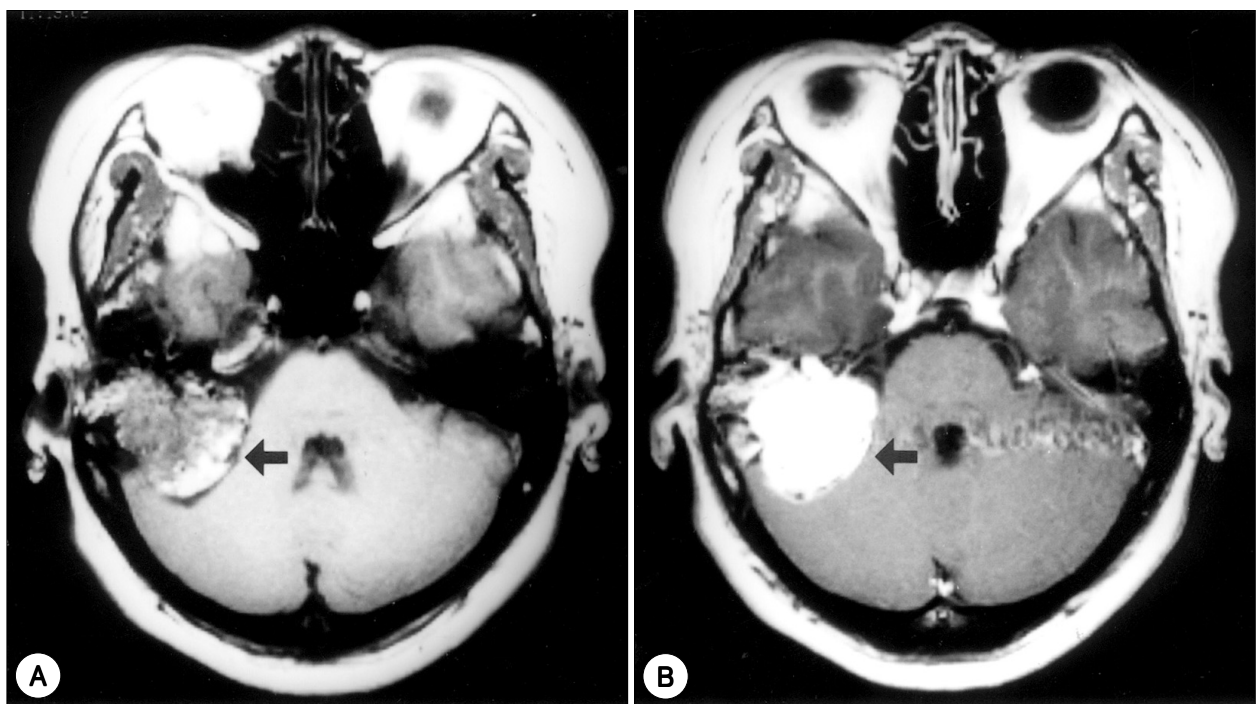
Preoperative MRI shows extensive lesion in right petrous bone and CPA (cerebellopontine angle) region. A : T1-weighted image. It shows heterogenous signal intensity in the mass. B : The mass is enhanced homogeneously with gadolinium.
